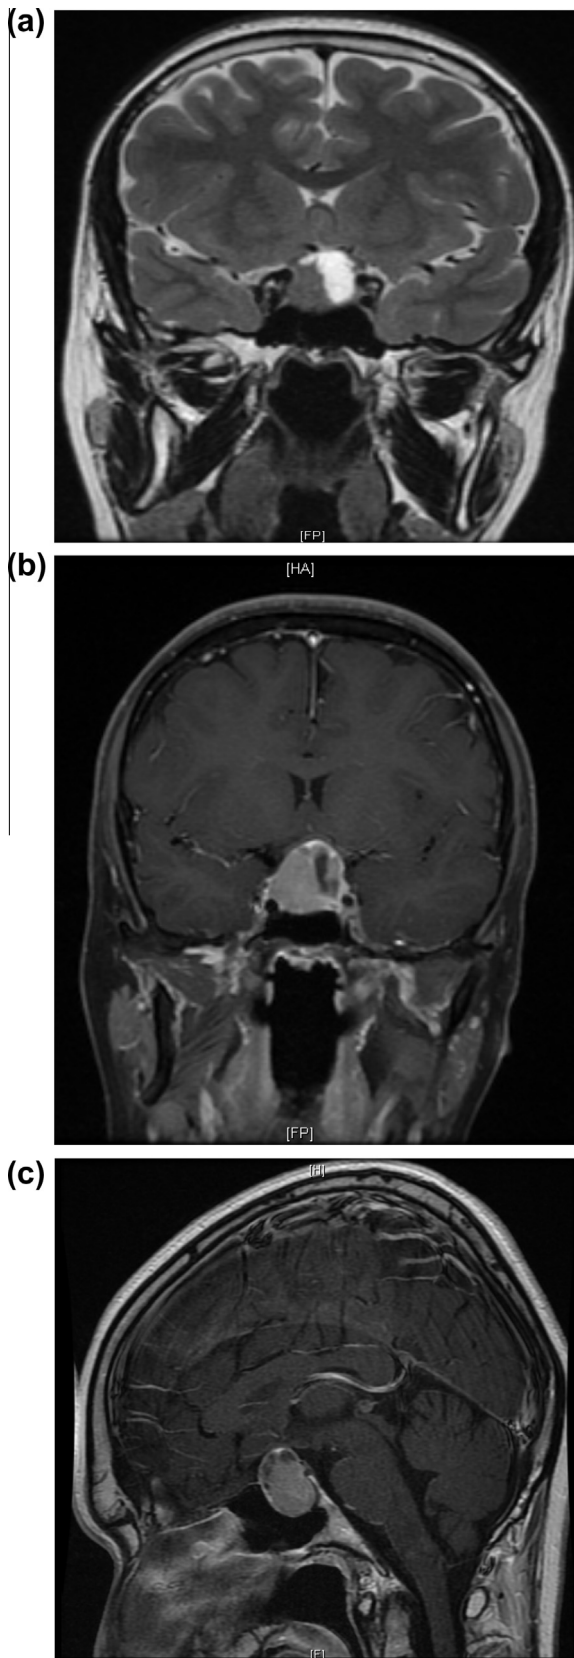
(a) Coronal T2-weighted MRI showing a large sellar lesion with suprasellar extension, (b) coronal T1-weighted contrast enhanced MRI showing a large heterogeneous sellar mass with cystic components with displacement of the pituitary stalk and optic chiasma, and (c) sagittal T1-weighted contrast enhanced MRI showing a large heterogeneous sellar mass with displacement of the pituitary stalk.
